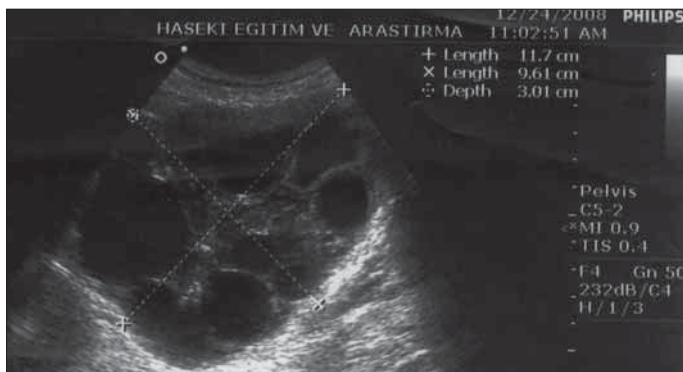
Transvaginal sonography 11x9 cm hypoechoogenic multiloculated cystic mass in the left ovarian location
